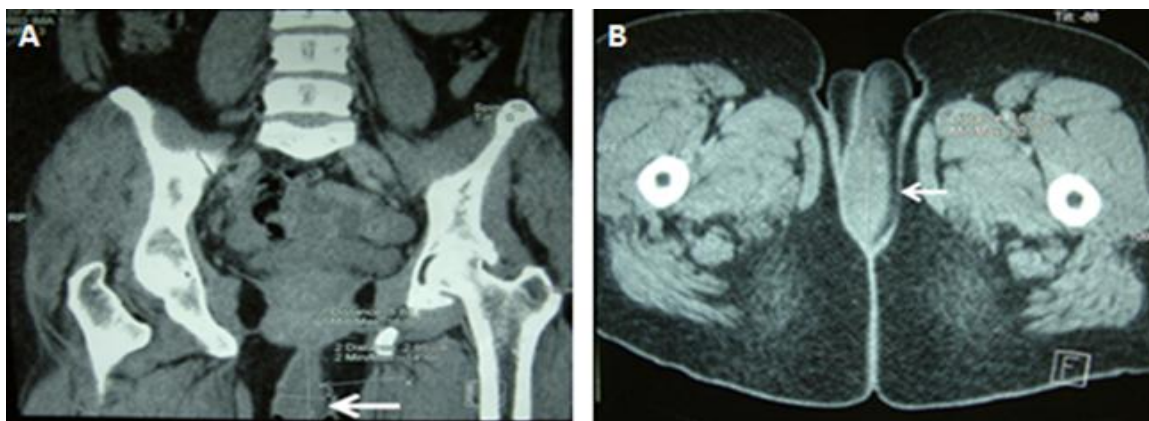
CT scan (A: Coronal section/ B: Axial section) showing an ovoid hypodense mass in the left labia majora (A: white arrow), heterogeneous after contrast-enhanced (B: white arrow).
